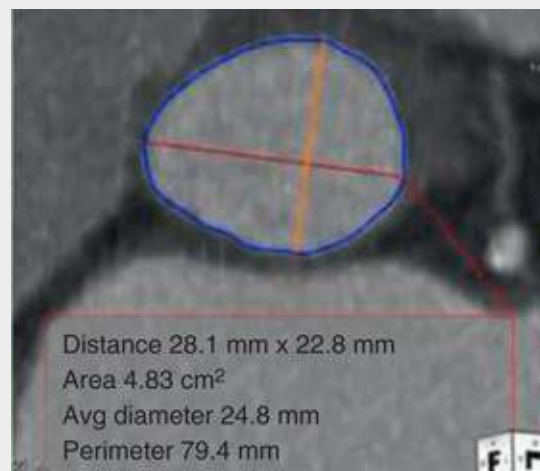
Three-dimensional reconstruction of a multislice CT scan for annular sizing for TAVR.
